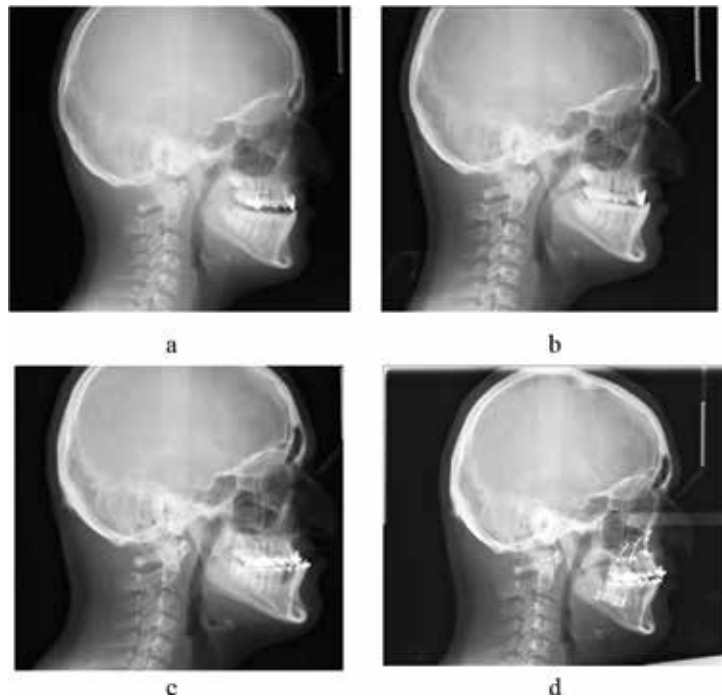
Cephalometric radiographs of the patient after facemask therapy between 10 and 19 years of age and after orthognathic surgery. (a) age 10, after face mask therapy, (b) age 14, follow-up, (c) age 19, pre-orthognathic surgery, (d) after orthognathic surgery.
